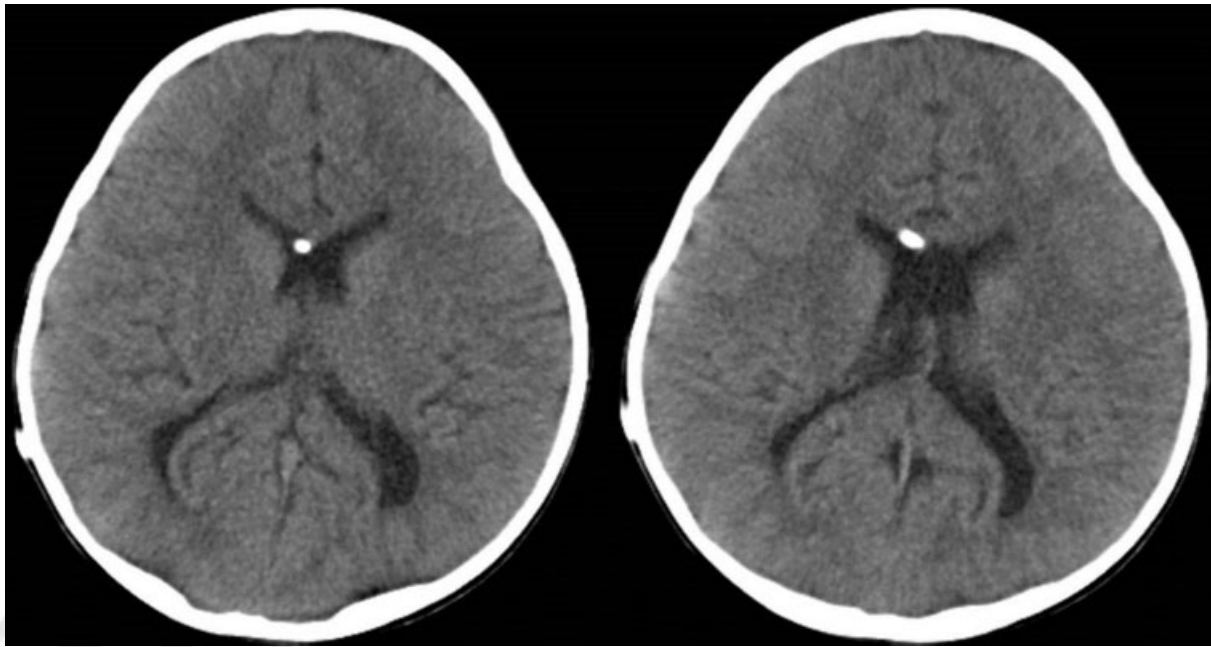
Brain computed tomography demonstrated reduction in ventricular size.
